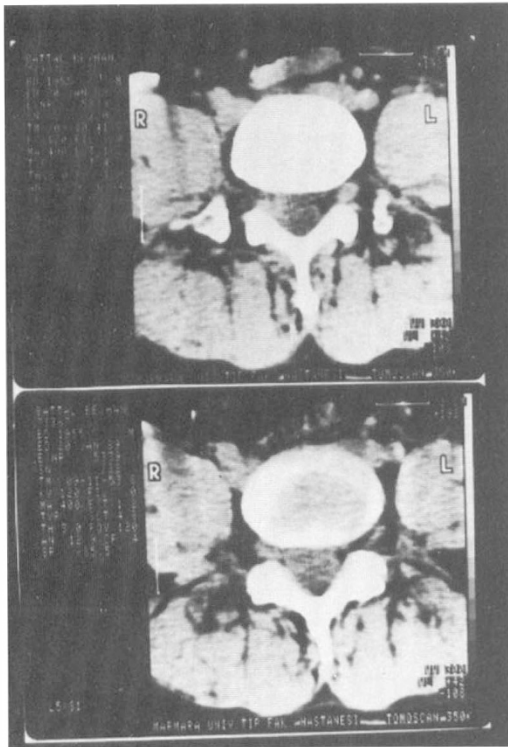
CT scan at the L5-S1 level revealed increased soft tissue density on the right side. Epidural fat tissue was detectable only on the left side.
